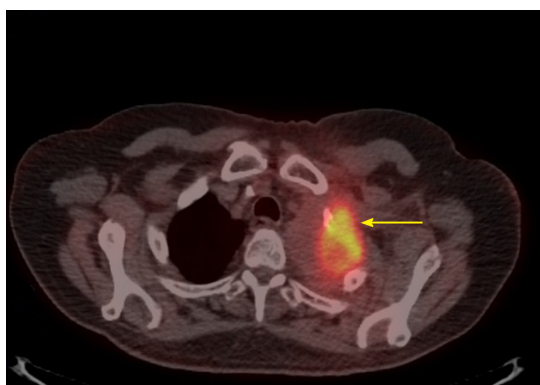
Chest positron emission tomography - computed tomography (lung window) after 9 cycles of pembrolizumab, with the yellow arrow pointing to a fluorodeoxyglucose-avid 5.5 cm × 4 cm mass in the left upper lobe, with central necrosis and a maximum standardized uptake value of 8.6, consistent with malignancy. Inferiorly and in its continuation, there is a second lesion measuring 2.3 cm × 1.8 cm with a maximum standardized uptake value of 7.2, interpreted as a remnant from the initial tumor.
